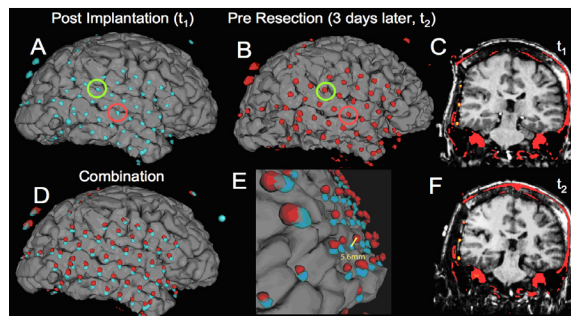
Displacement of electrodes over the duration of three days. A. Post surgical (t_1) implantation of subdural grid electrodes MRI+CT. B. Pre-resection MRI+CT data collected three days
